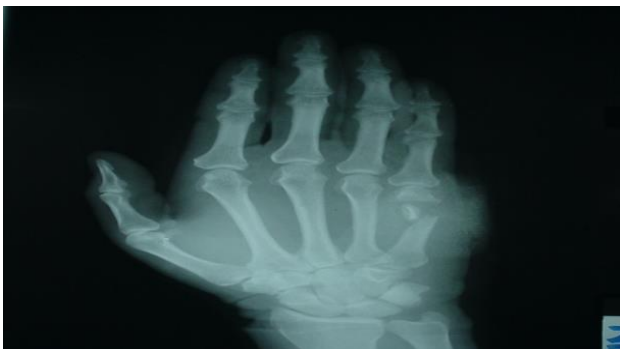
Pre-surgical X-ray of the bone defect (Dr. Ricardo Pacheco López).
